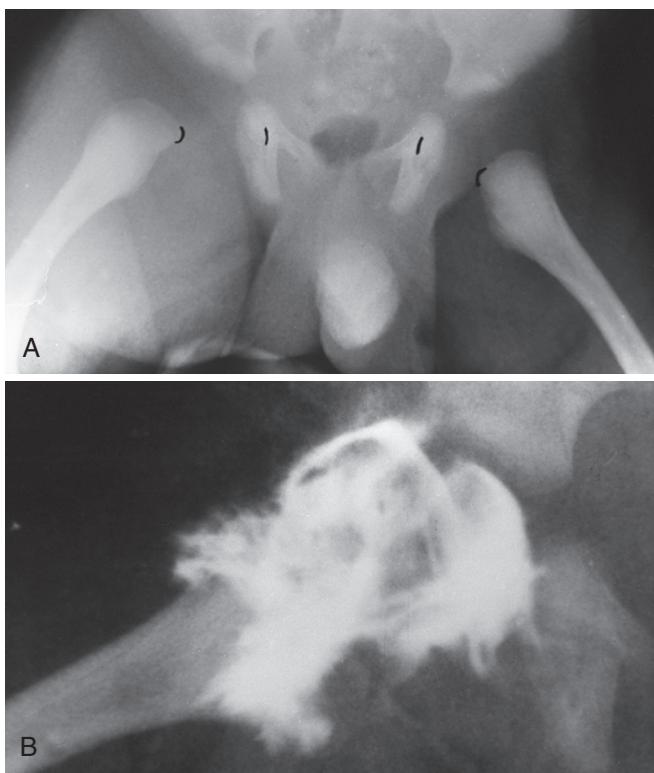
A, Anteroposterior pelvic radiograph of a 2-week-old boy who had been irritable during diaper changes for 1 week. There were no systemic symptoms, such as fever, although the child had been quite irritable and not feeding normally. The femoral heads are not visible, because they do not begin to ossify until 4-6 months of age. Observe the widening between the acetabulum and the ossified medial corner of the proximal femoral metaphysis, which indicates lateral displacement or subluxation of the femoral head. B, Arthrocentesis revealed only a small amount of purulent material. An attempted arthrogram revealed gross distortion of the hip joint caused by inspissated purulent material. At the time of hip arthrotomy, clotted, purulent material was removed. This child subsequently developed avascular necrosis as a consequence of septic arthritis with subluxation. Fortunately, he made a satisfactory recovery and regained essentially normal hip function.
